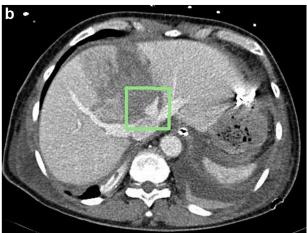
60-year old female. Skiing accident. Computerized tomography (CT) on arrival (a): severe extravasation due to rupture of the middle hepatic vein with blush extending to the abdominal cavity (arrows). Patient developed shock in the radiology suite during CT scan, leading to urgent intervention with perihepatic packing. Repeat CT prior to removal of packing on day 5 (b) shows no active bleeding and the stump of the middle hepatic vein. Uncomplicated course thereafter.
